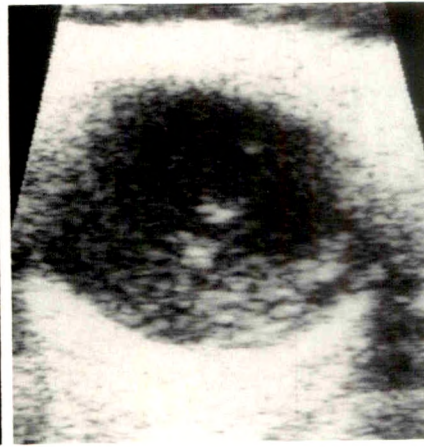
Acute hemorrhage in a diabetic patient. Despite dense hemorrhage in vitreous chamber that precluded visualization of fundus, only a few low-amplitude echoes are seen on sonogram obtained approximately 12 hr after onset of bleeding.
